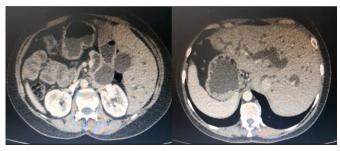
Computed tomography of the abdomen highlighting the altered anatomy in the patient with *situs inversus totalis*.
